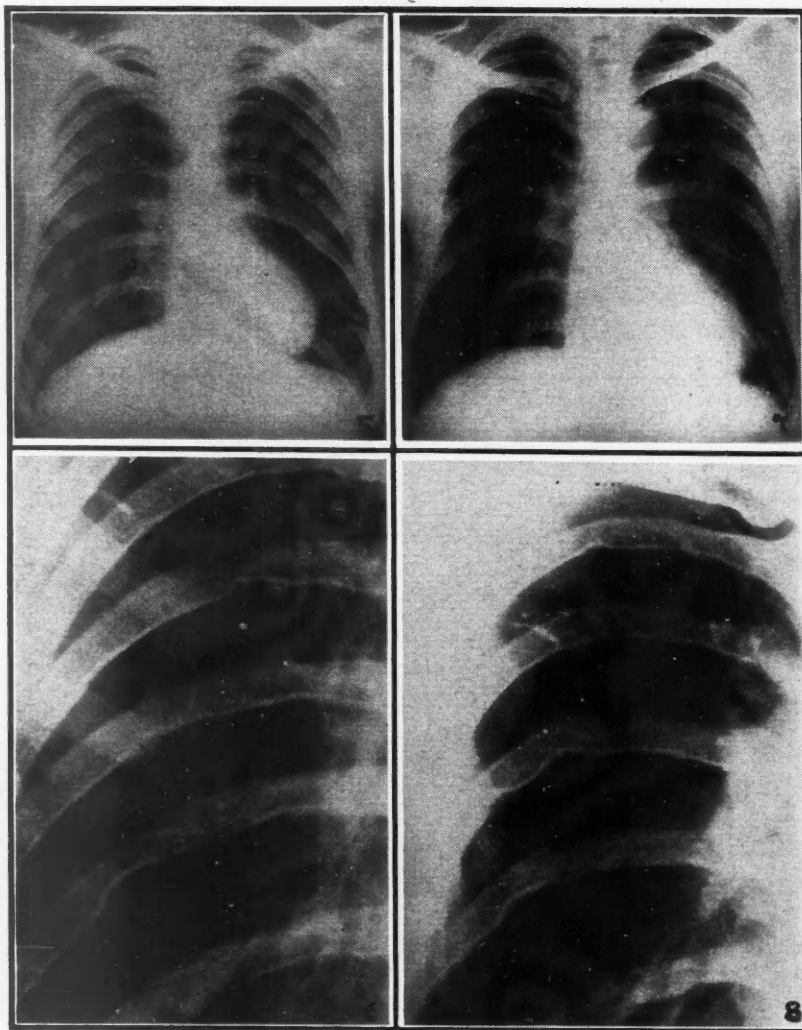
Radiograph of the chest, Case 1. Note rib notchings. Fig. 6.—More detailed view of Fig. 5 to show rib defects. Fig. 7.—Radiograph of the chest, Case 2. Rosler's sign also can be seen in ribs. Fig. 8.—More detailed view of Fig. 7 to show rib defects.
